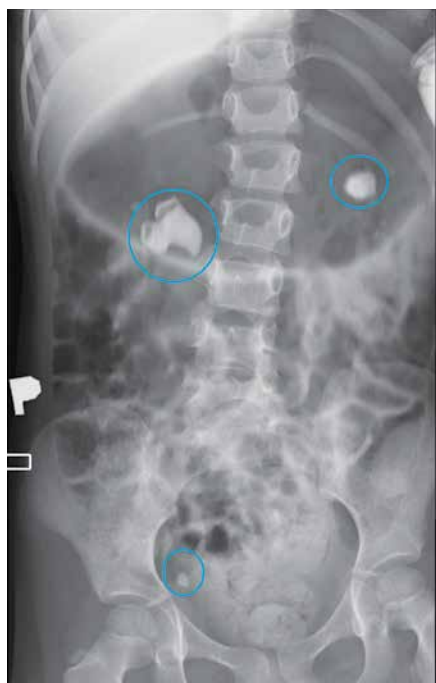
X-ray – abdominal view
